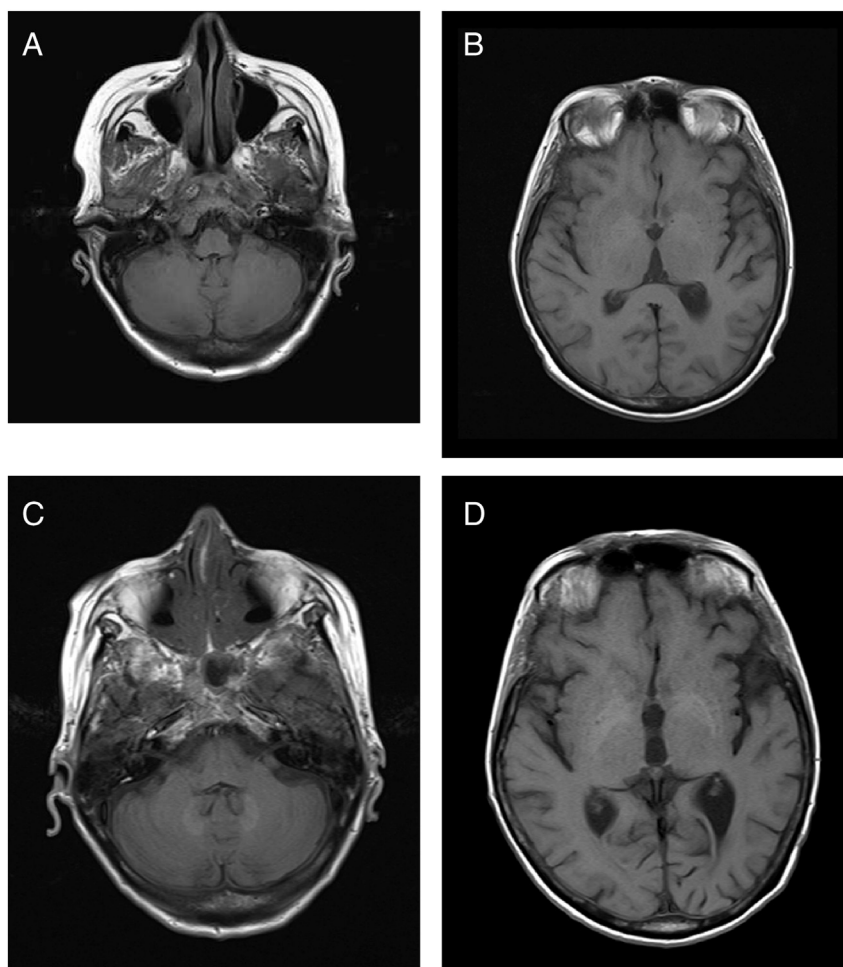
Axial pre-contrast T1 weighted images showing the typical finding of hyperintensities in DN and GP. Images were acquired from the first MRI (A,B) and sixth MRI (C,D) with linear GBCA.
